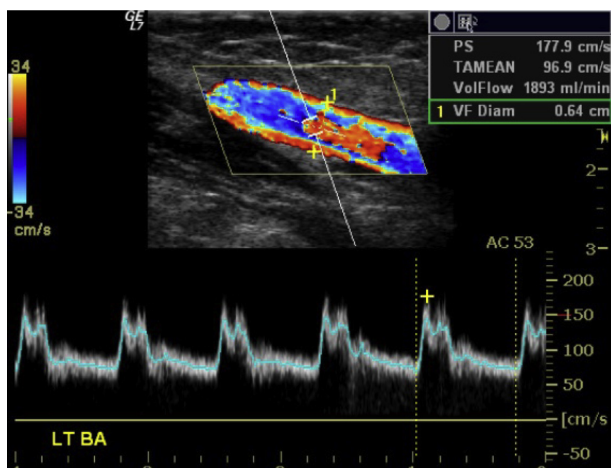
Doppler ultrasound image demonstrating measurement of volume flow within the brachial artery.
